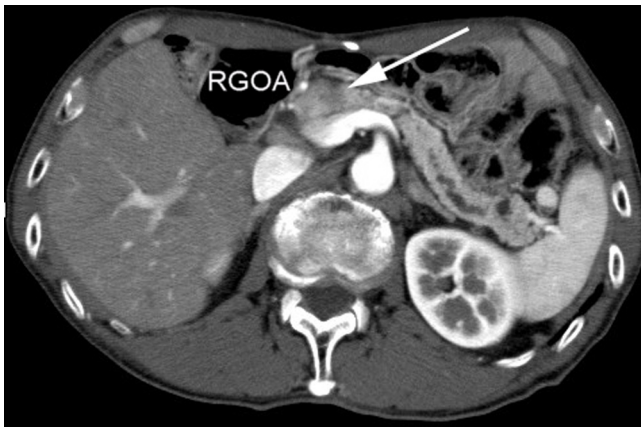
Preoperative view of enhanced CT scan. The pancreatic head tumor is shown by the arrow. Tumor was adjacent to the right gastro-omental artery (RGOA).
